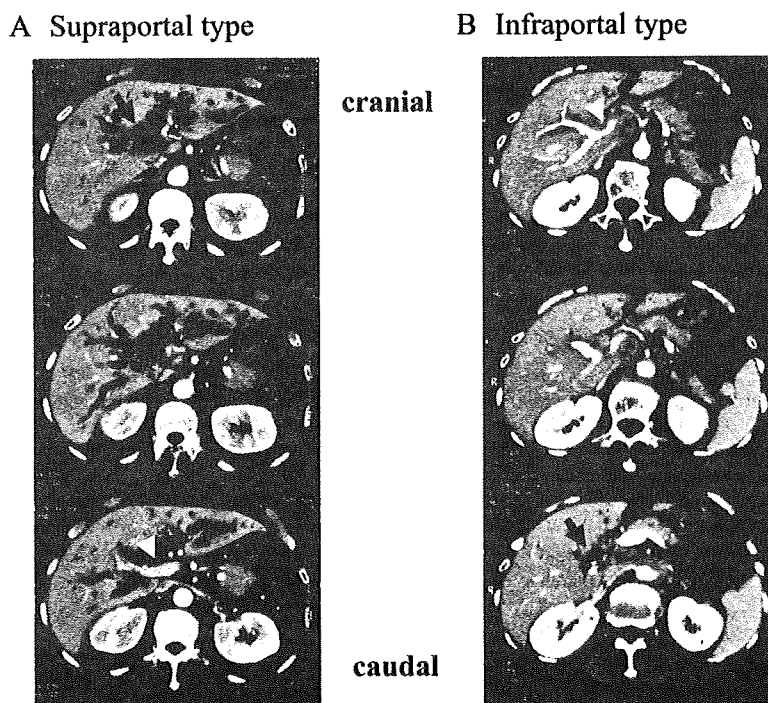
Diagnosis of the confluence pattern of the right posterior sectional bile duct (RPSBD) using contrast enhanced computed tomography. (A); Supraportal type, the RPSBD (arrow) joins to the distal bile duct at cranial side of the right portal vein (RPV) (arrowhead). (B); Infraportal type, the RPSBD (arrow) joins to the distal bile duct at caudal side of the RPV (arrowhead).
